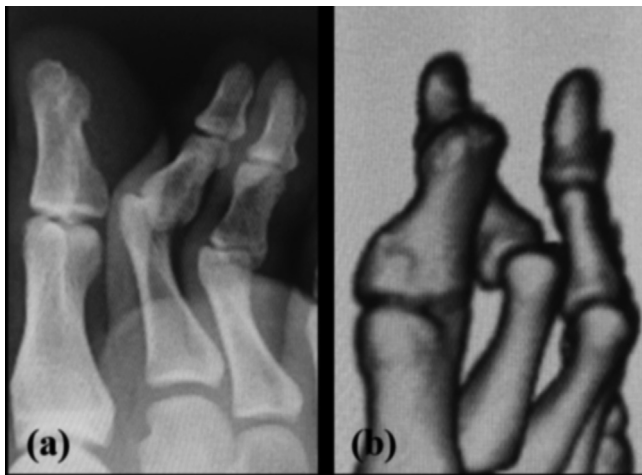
Radiographic examination. (a) Plain radiography and (b) computed tomography revealed no fracture or dislocation.
